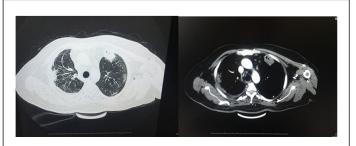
4 cm nodular lesion suggesting a ball of manar on the left apex in computed tomography.
